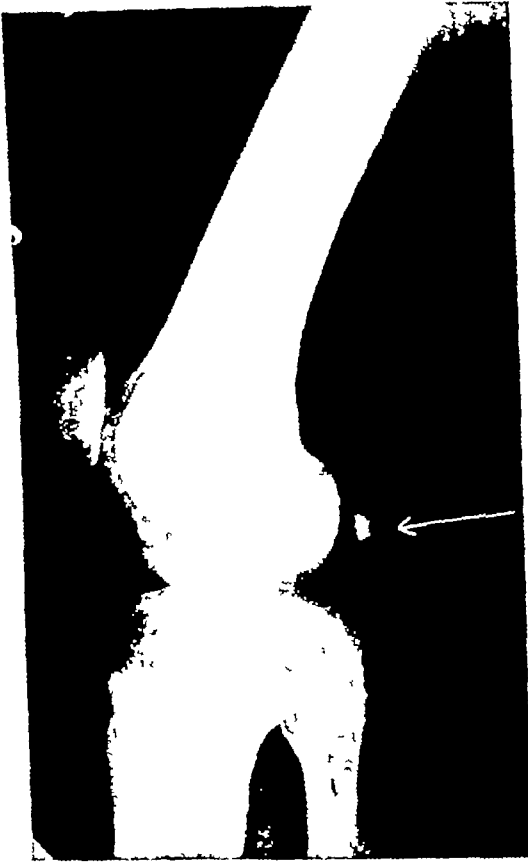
Lateral roentgenogram of an adult white male showing a fabella in the left knee presumably in the tendon of the gastrocnemius muscle
